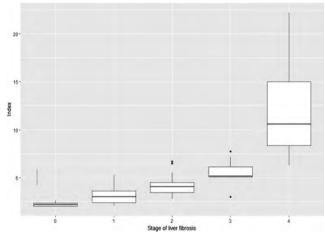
Stage liver fibrosis by Ultrasound Doppler measurement.
